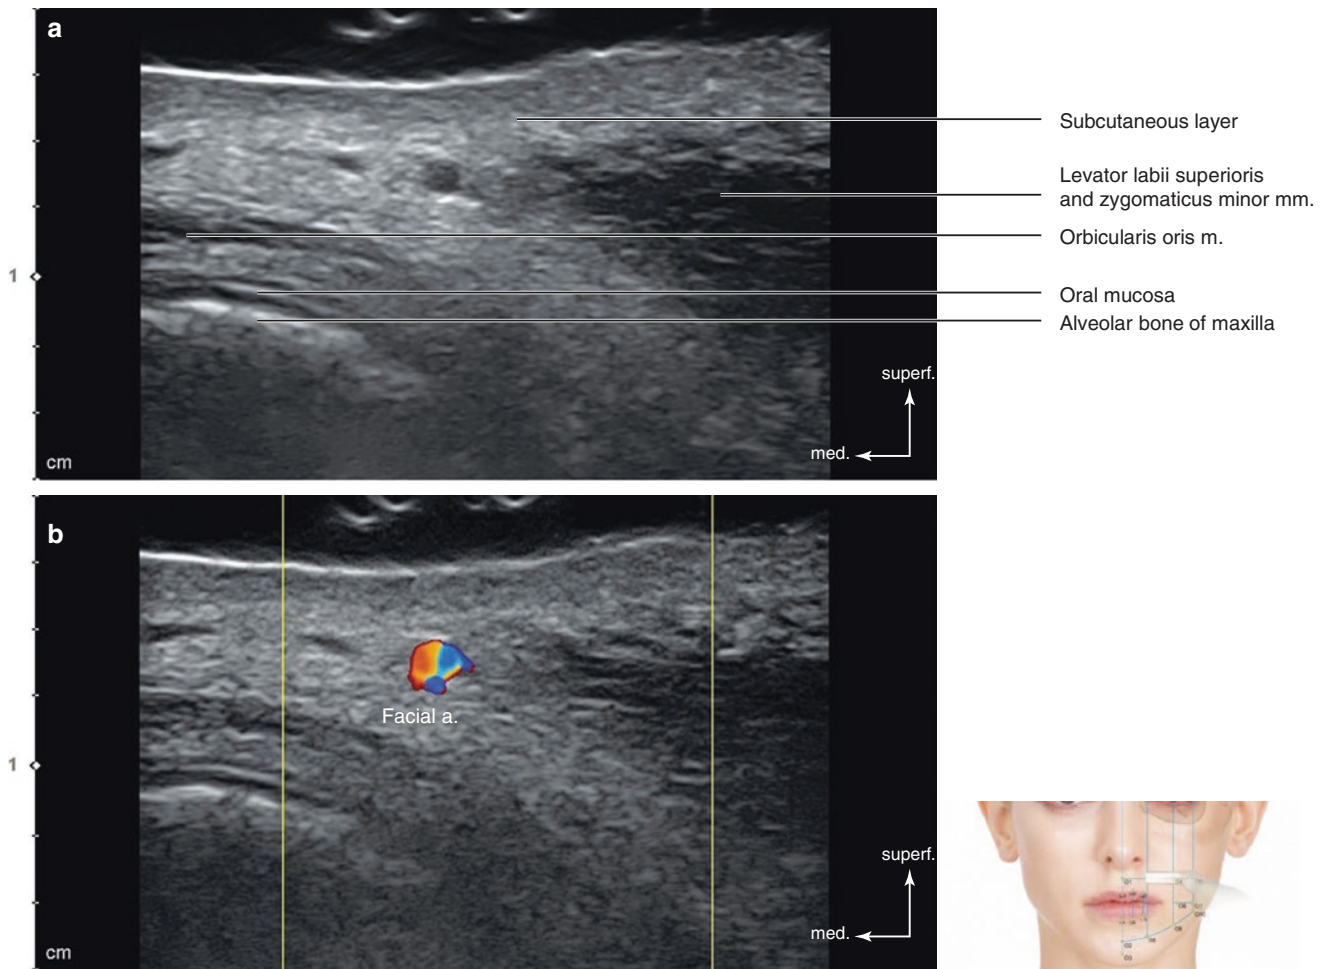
Ultrasonography of the intersection point of TL6 and PL2 (O4). (a) B mode (transverse view, 15 MHz by linear transducer) and (b) Doppler mode (transverse view, 15 MHz by linear transducer). (Published with kind permission of © Hee-Jin Kim 2020. All Rights Reserved)
